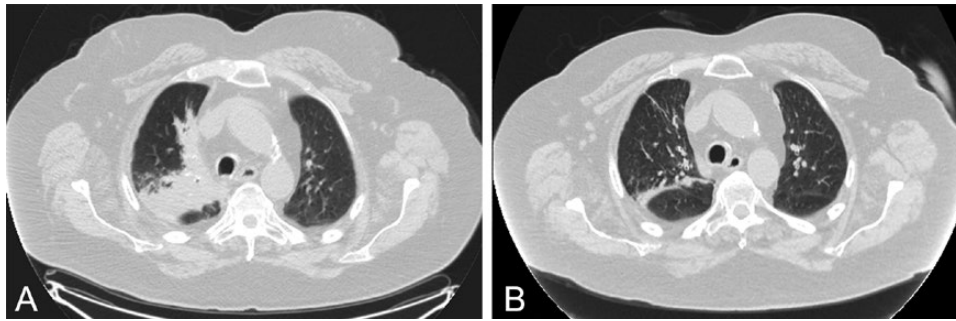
Computerized tomography (CT) scan of the chest done after 8 weeks of antibacterial therapy showing significant improvement in the right upper lobe consolidative process (B) compared with the pretreatment CT scan of the chest (A).
